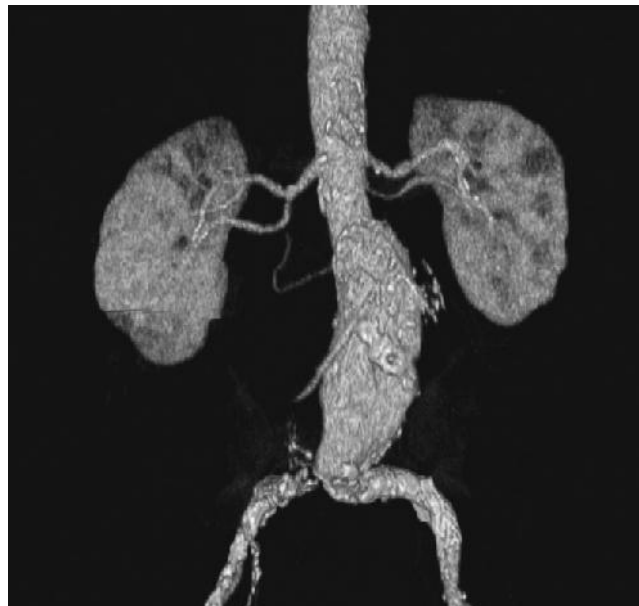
Computed tomographic angiogram of the distal abdominal aorta shows abdominal aortic aneurysm, 6.2 cm in largest diameter, with severe stenosis at the origin of the right common iliac artery. (Courtesy Bart Domatch, MD, Radiology Department, University of Texas Southwestern Medical Center, Dallas, Tex.)
